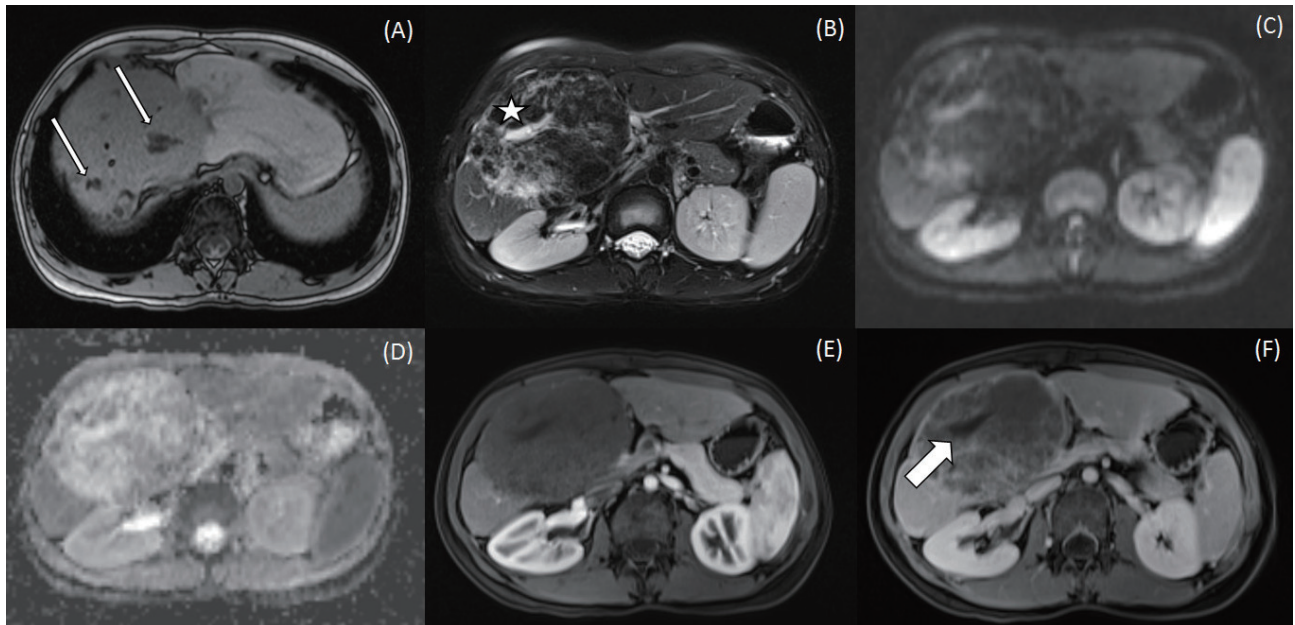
(A) Magnetic resonance imaging (MRI) with axial T1-weighted image (T1WI) showed a large homogeneous hypointense mass with several dark signals (white arrows) in segments 4 and 8. These dark signals represent the coarse calcifications noted on chest radiography. (B) MRI with axial T2-weighted image (T2WI) with fat saturation revealed a heterogeneous hyperintense tumor. Central necrosis (asterisk) presented as an irregular cavity inside the tumor. (C) MRI with diffusion-weighted imaging (DWI) showed heterogeneous dark signal intensity, and (D) apparent diffusion coefficient (ADC) map revealed heterogeneous bright signal intensity. (E) MRI with contrast enhancement in the arterial phase showed no evident tumor enhancement. (F) Contrast-enhanced MRI in the venous phase revealed mild inhomogeneous enhancement, which is limited to the septa and stromal components.
